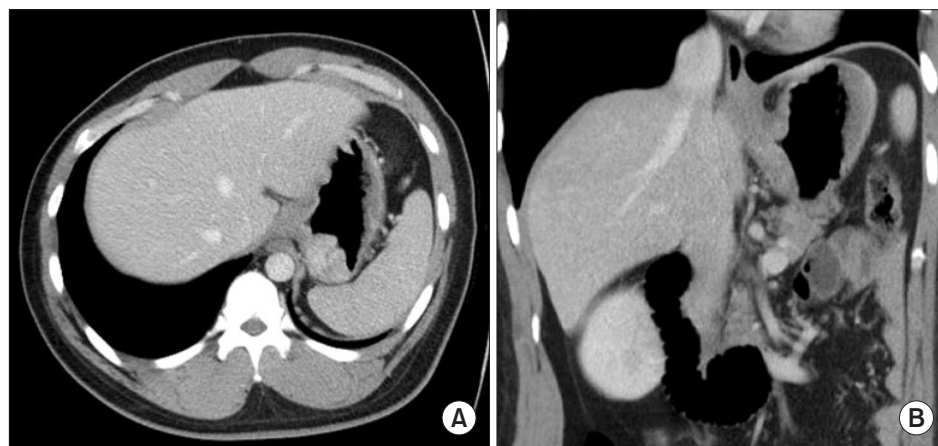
Computed tomography scan shows fundic mass with diffusely thickened gastric wall on the lesser curvature side of the upper body and cardia. (A) Axial image. (B) Coronal image.
